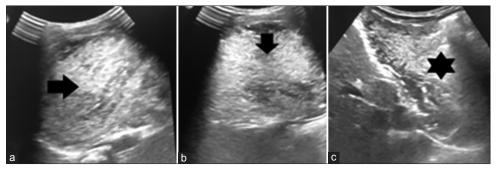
Follow-up abdominal ultrasonography of the same child, (a) Axial and (b) sagittal section of stomach did not reveal any residual lactobezoar (black arrows), (c) oblique section of the pylorus region show clear walls with the dissolution and disappearance lactobezoar mass (black star)
